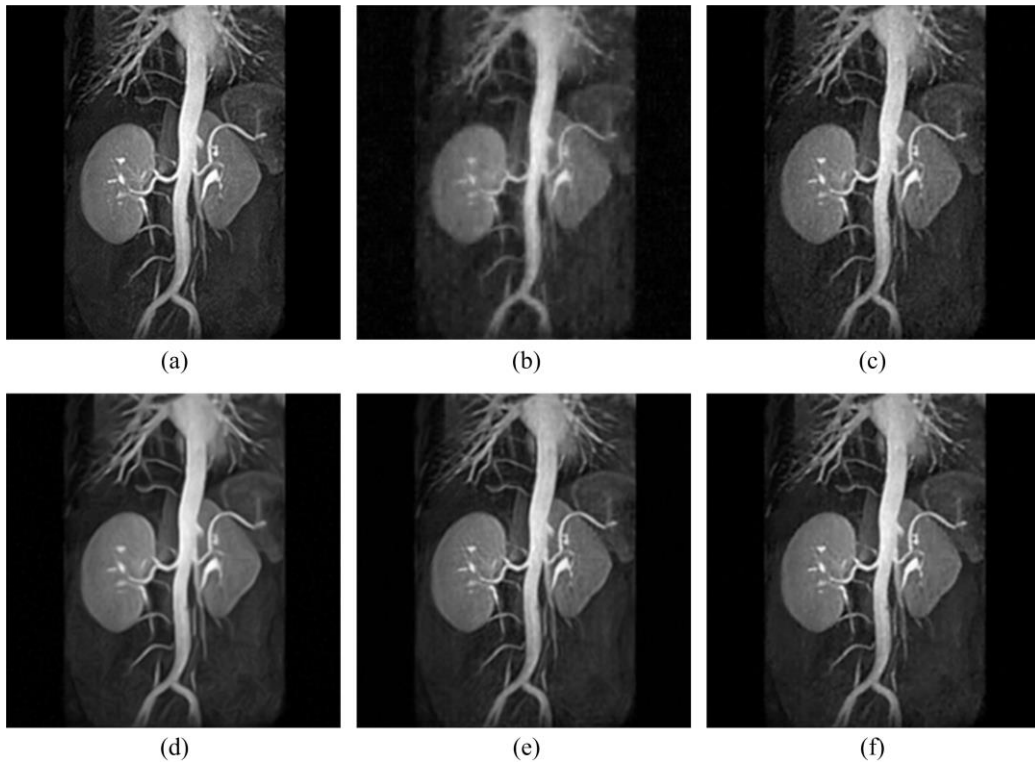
Results of reconstruction on the renal arteries MR image using different methods with 15% sampling. (a) Original MR images; images reconstructed using, (b) SparseMRI, (c) FCSA, (d) Framelet+NLTv, (e) Shearlet+TGV, (f) Data-driven TF+TGV (proposed).
